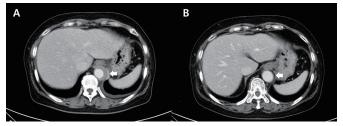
Postcontrast CT scans before and after cyclophosphamide pulse therapies
